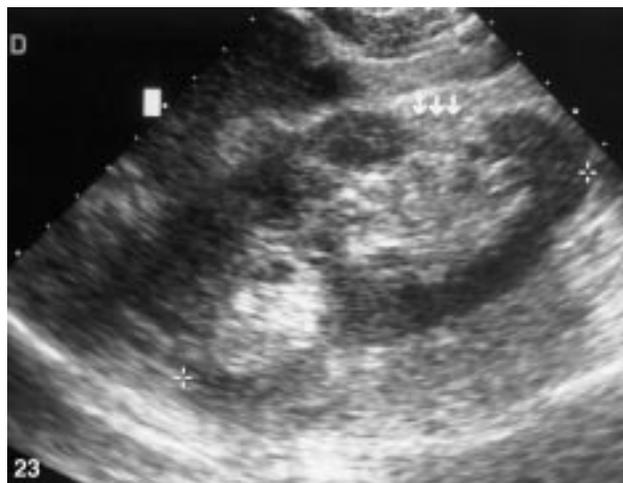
Renal abscess. Sagittal sonogram of the right kidney demonstrating a focal hypoechoic lesion with contained debris consistent with a renal abscess. Needle aspiration confirmed renal abscess, which responded rapidly to appropriate antibiotics.
